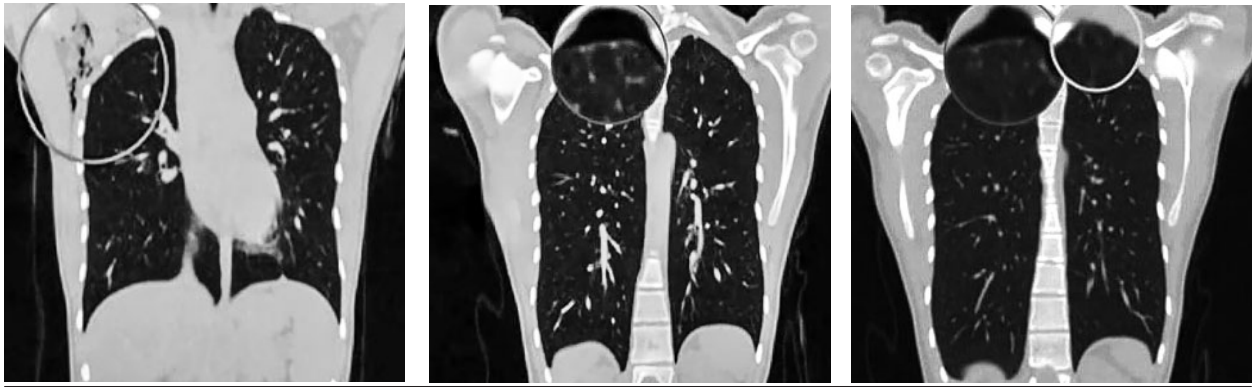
Chest CT scan (May 28, 2019)
